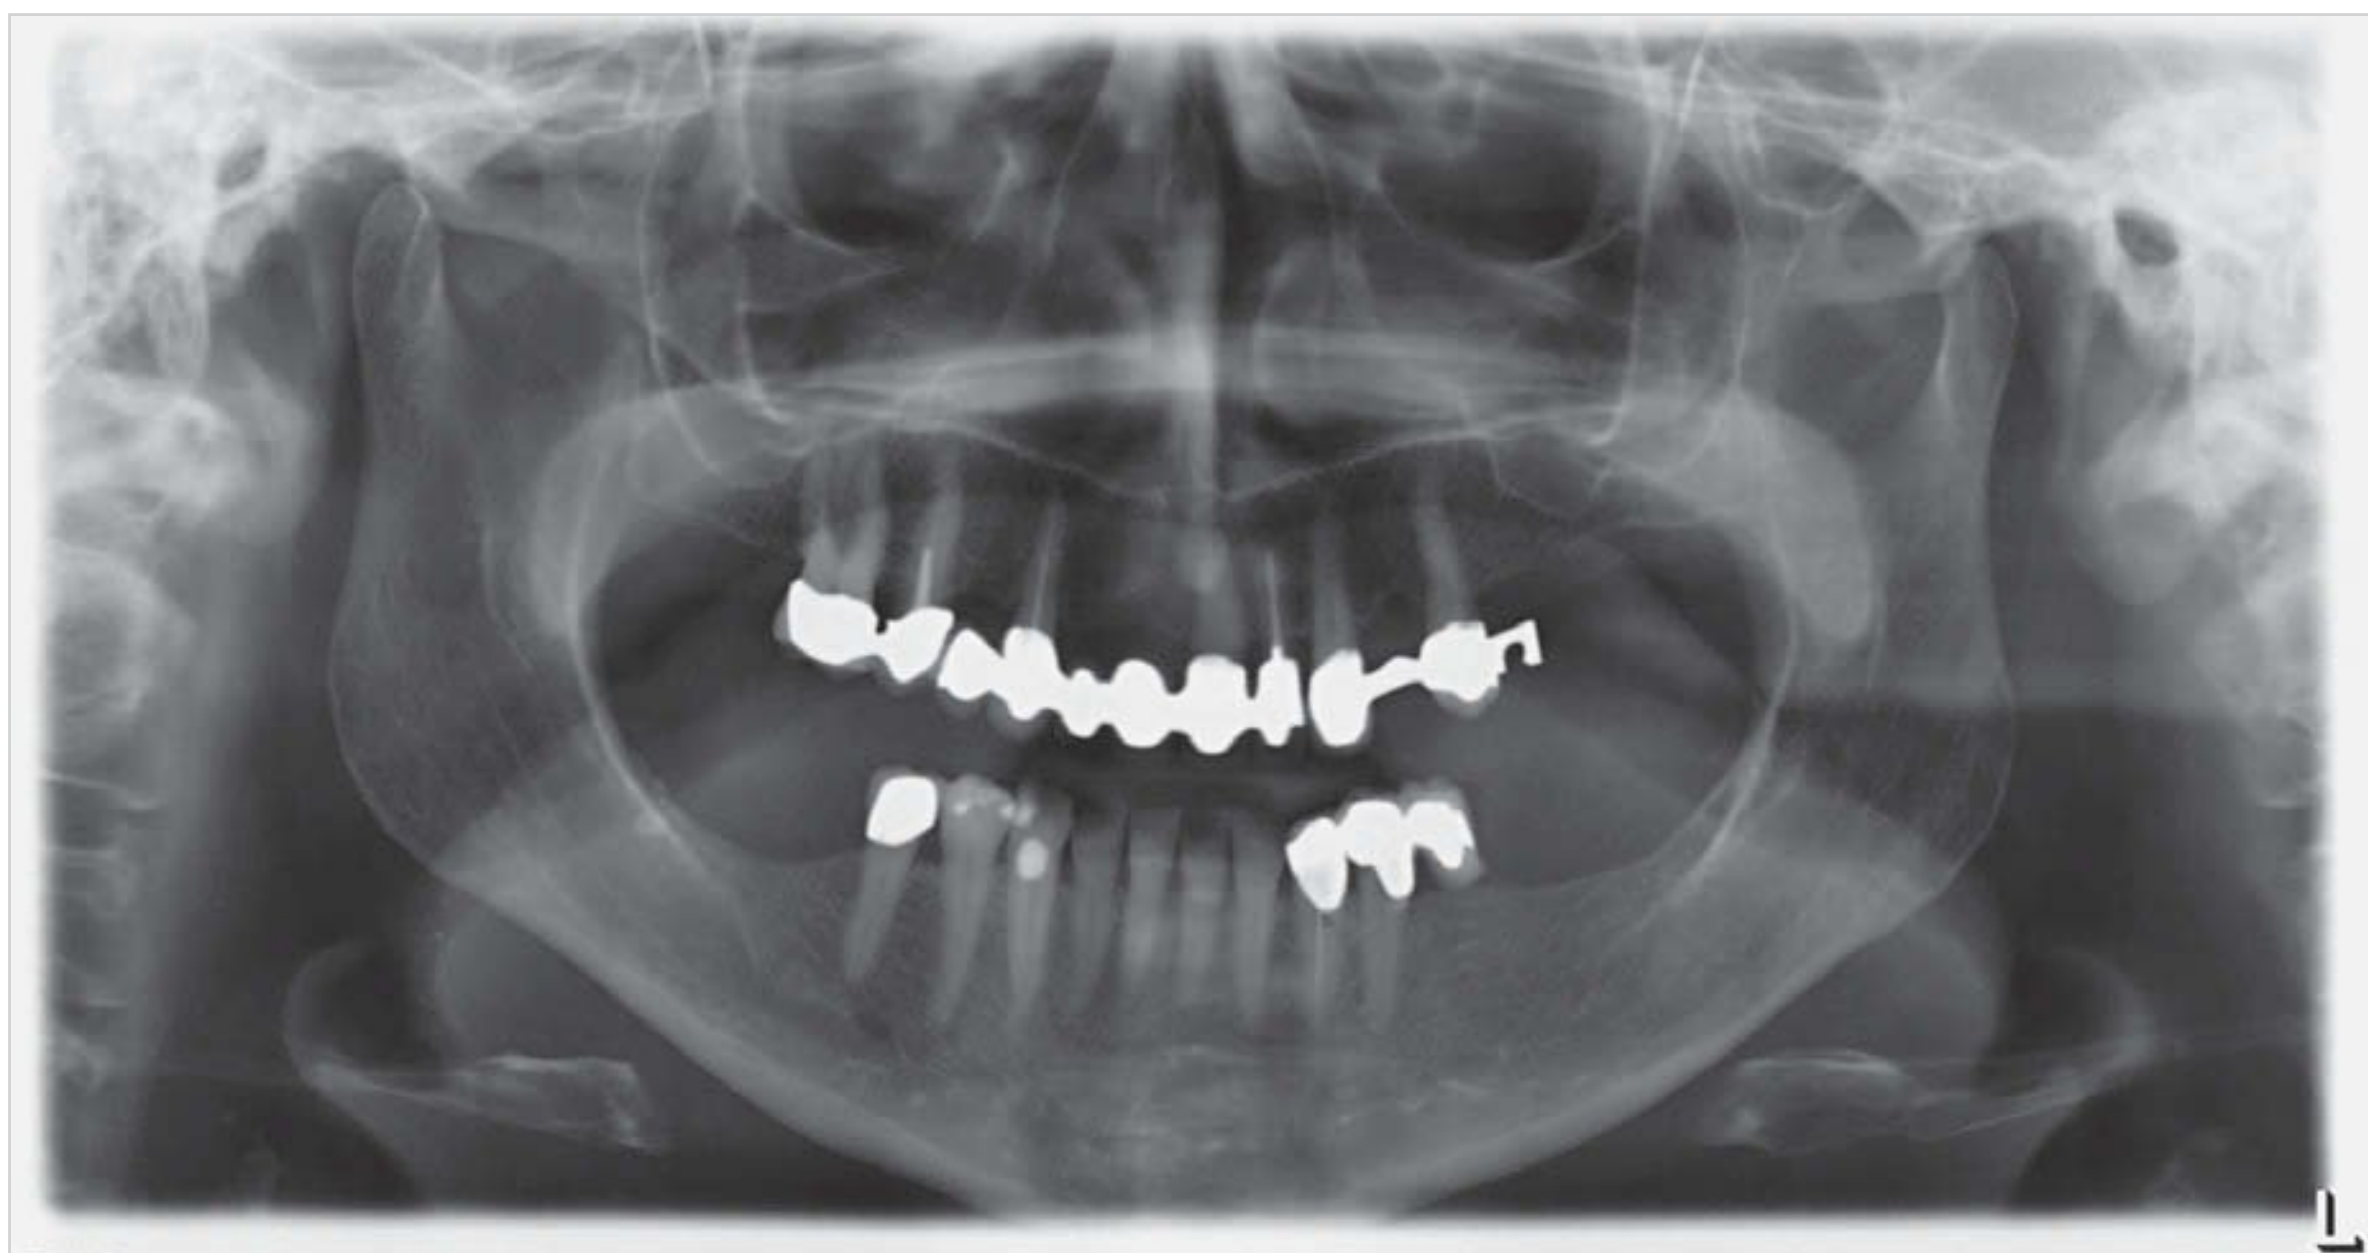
Panoramic radiograph taken with the head slanted to the side.
